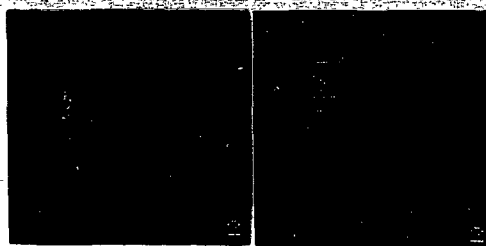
40-41 Cholescintigraphy in a patient with probably acute viral hepatitis; after clinical improvement.
